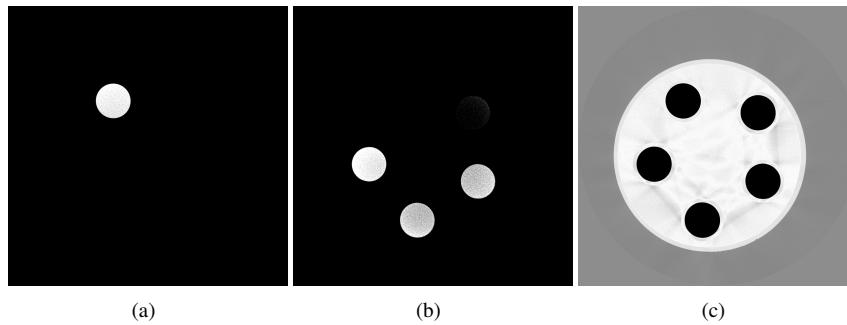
Decomposition in three basis materials of the CT slices from figure 4.13 showing the calculated volume fractions of the $\text{Ba}(\text{ClO}_3)_2$ solution (a), the KBr solution (b) and water (c). A threshold of 0.5 was applied for each image.
